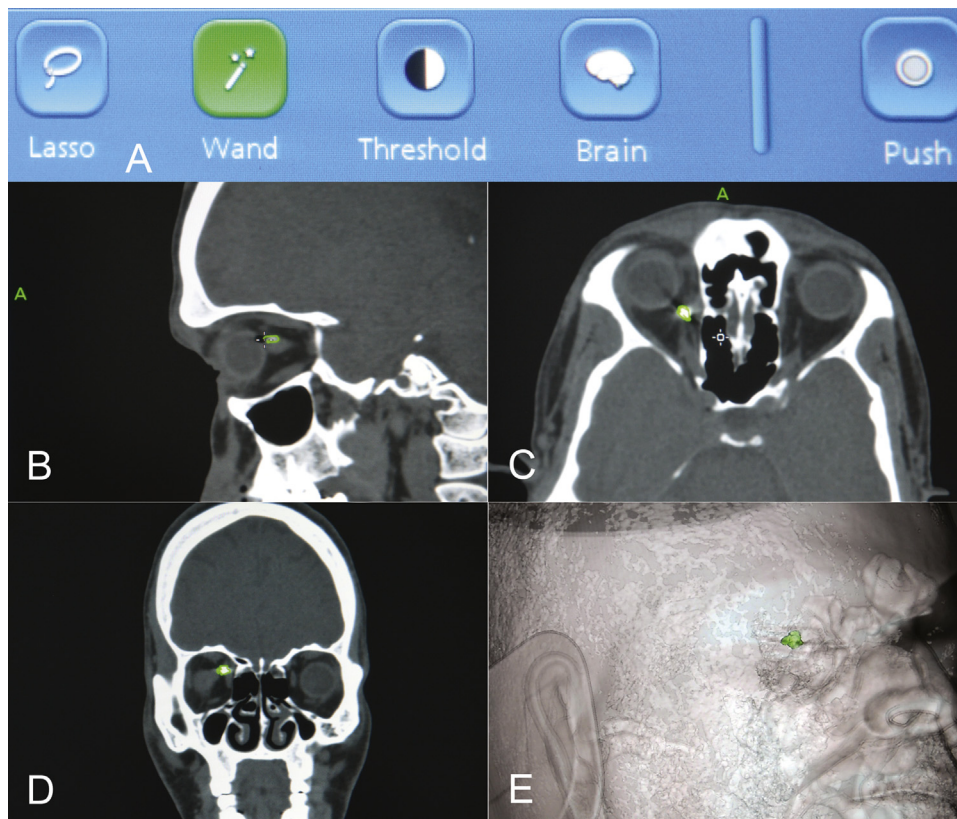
Steps of 3D reconstruction of a foreign body. Software bar showing the various 3D reconstruction options for the surgeon (A). Computed tomography scan, sagittal section, showing the surgeon marking the boundaries of the foreign body (B). The foreign body is delineated in axial (C) and coronal (D) cuts. Three-dimensional reconstruction of the foreign body (green) ready for 3D navigation (E).
